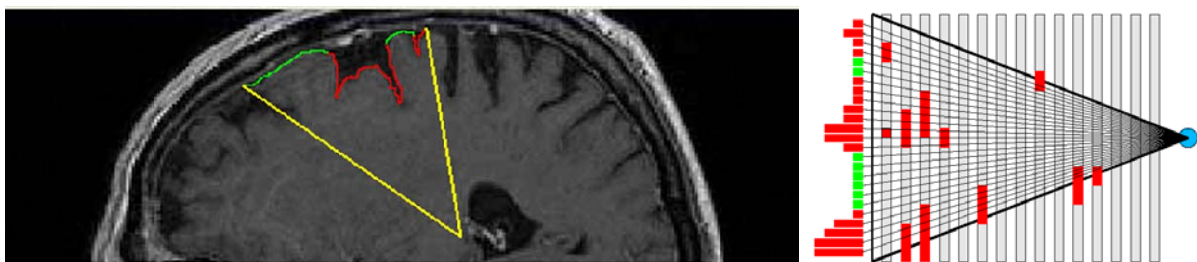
Selection of entry points and trajectories; left accepted (green) and rejected entry points in entry funnel (yellow); right: critical areas in any T1-MRI slices and rejected trajectories (red)
